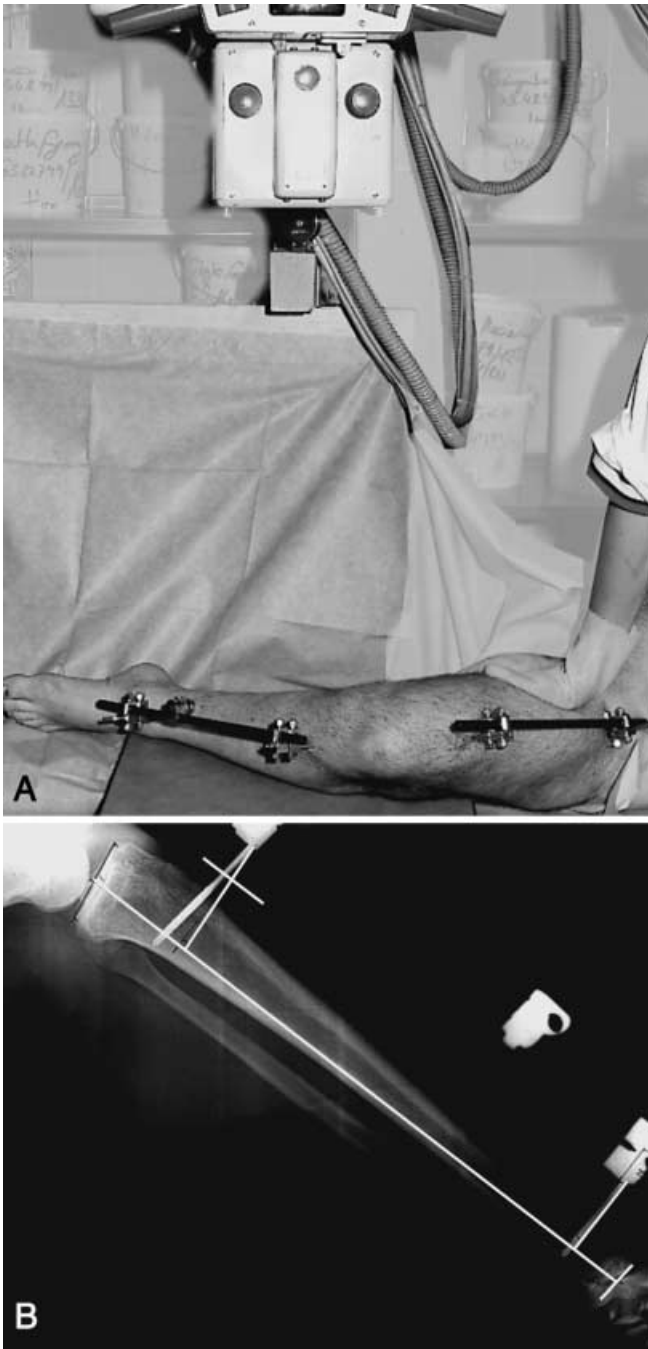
After an external fixation device was applied, radiographs of the entire femur and tibia were taken at 90° of knee flexion. Lines were drawn from the middle of the ankle joint to the middle of the tibial plateau. Another line indicated the posterior cortex of the tibia within 15 cm of the joint line. The bar of the external fixator was brought into a parallel position with the constructed axis of the tibia. The procedure was performed by analogy for the femoral lines and fixation bars
